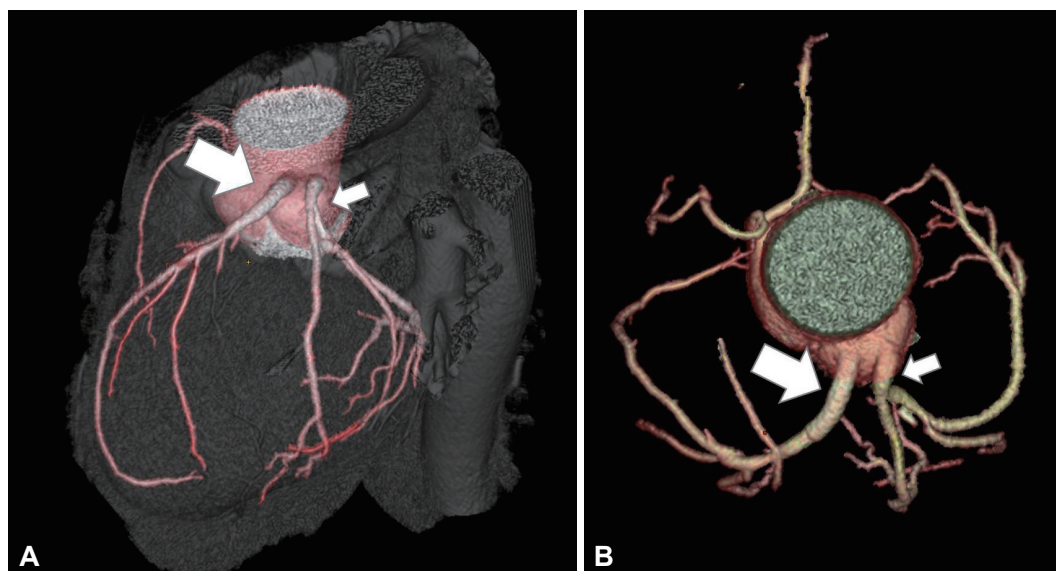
Coronary CT angiography showing anomalous separate origin of LAD (large arrow) and LCX (small arrow) from the left coronary aortic sinus. A: LAO cranial view of a three-dimensional volume rendered image. B: top view of a volume-rendered coronary tree image. LAD: left anterior descending artery, LAO: left anterior oblique, LCX: left circumflex artery.
